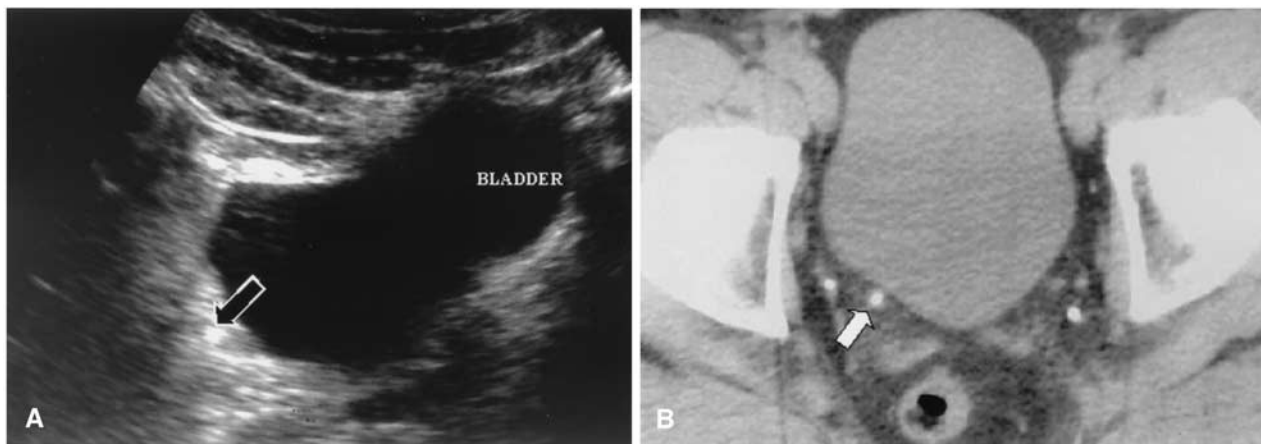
Lower abdominal pain in a 45-year-old man. A Transverse US scan shows a lithiasis (*arrow*) near the right ureterovesical junction. US also demonstrated hydronephrosis and ureteral dilatation (not shown). B CT demonstrates a stone (*arrow*) in the distal right ureter just above the ureterovesical junction with a positive rim sign. At the same level are two phleboliths on each side.
